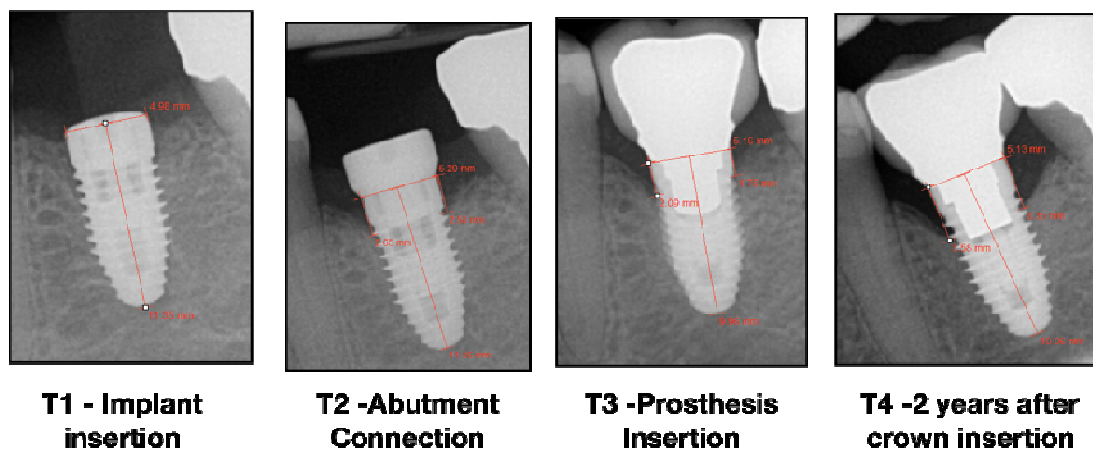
Measurements recorded for dental implants on peri-apical radiographs. Linear measurements were recorded from implant shoulder to first alveolar bone crest to implant contact at mesial and distal surfaces.
